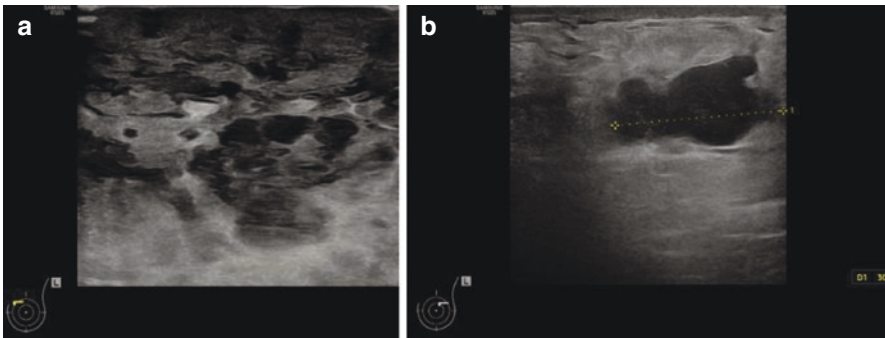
An 86-year-old woman presenting with peau d'orange and enlarged left breast thought to represent a locally advanced breast cancer. Ultrasound shows (a) dermal and subcutaneous nodules and inflammatory change as well as (b) multiple lobulated masses. Core biopsy shows this to be lymphoma
